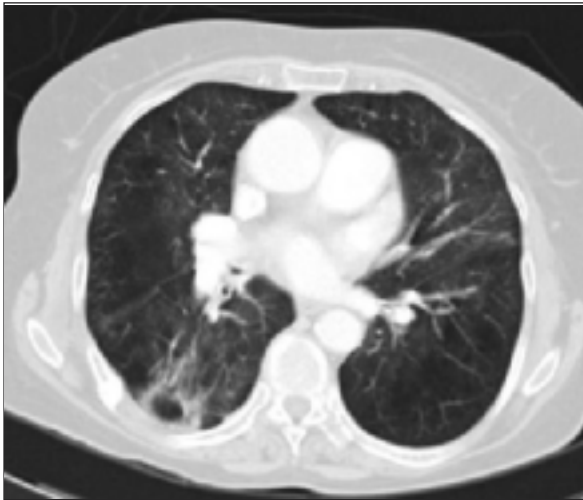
Chest computed tomography, 6 months after the treatment.
